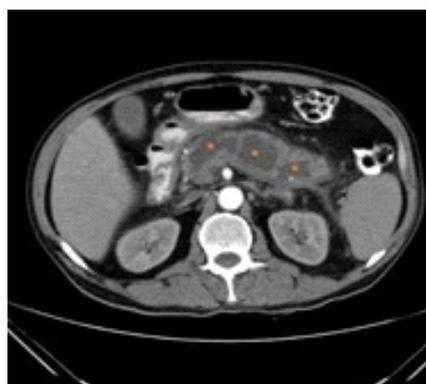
Axial enhanced CT shows that multiple acute necrotic collection in pancreatic bed (Asterisks)
